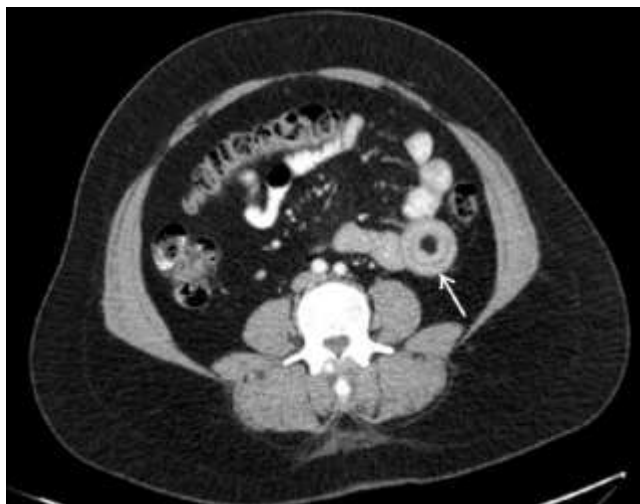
Intussusception due to lipoma in Meckel's diverticulum (Abdominal Computed tomography)
